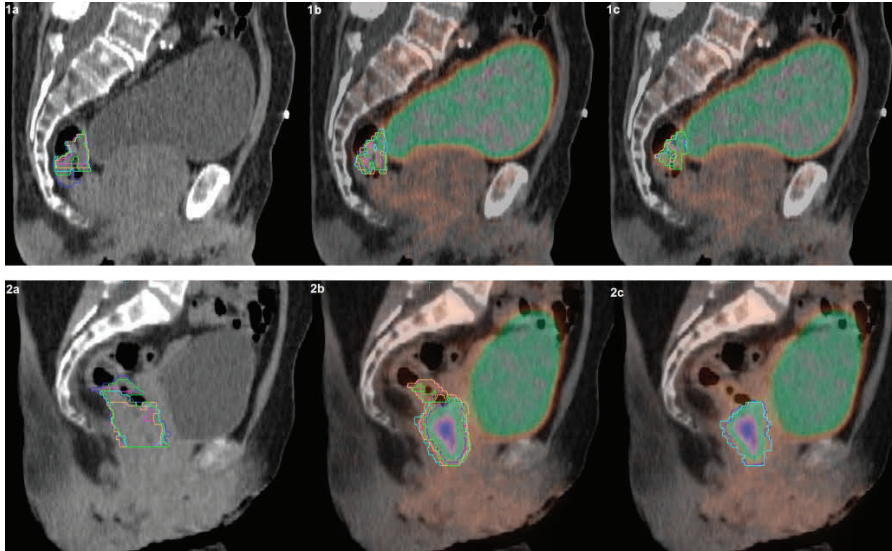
Example of the delineations by 5 observers in a patient with a high-seated (1) and a low-seated tumor (2), based on CT-only (a), PET-CT (b) and PET-CT with auto-contour (c).
